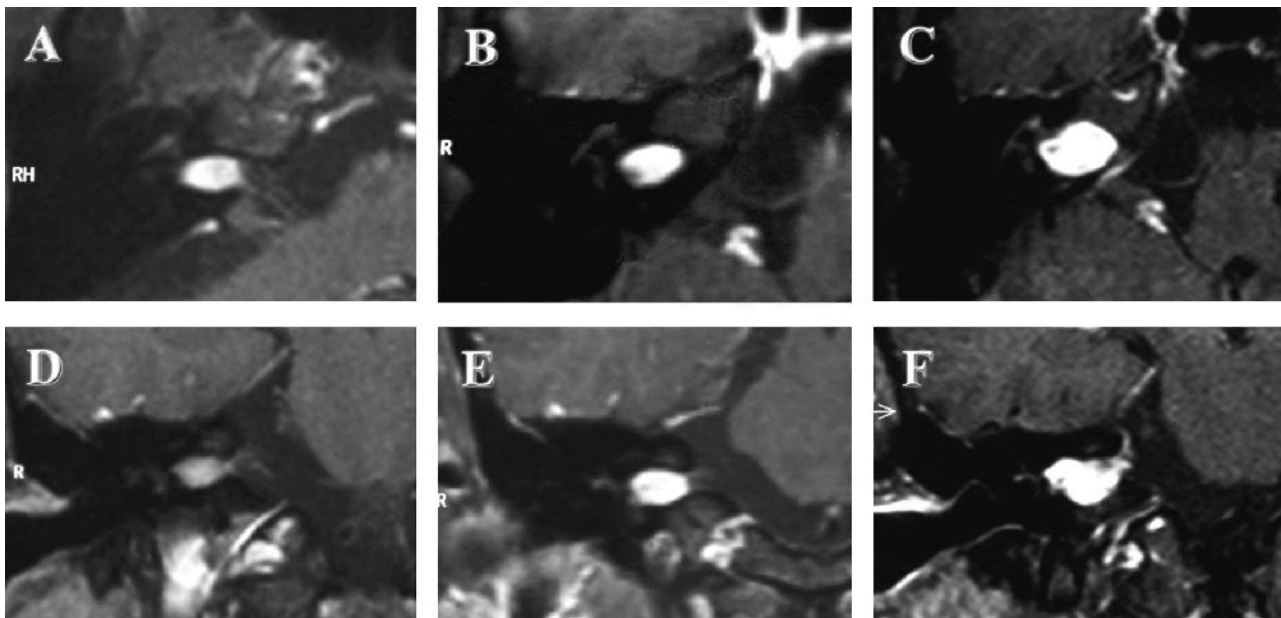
T1-weighted, post-gadolinium-enhanced MRI scans of the cerebellopontine angle from Case 1. Axial images (A–C) and coronal sections (D–F). (A and D) Pre-gamma knife MRI scans demonstrating a right-sided 1.0-cm VS, with scans at 6 months (B and E) and 20 months (C and F) after radiation. Slight tumor involution seen in B was followed by rapid regrowth to 1.5 cm at 1 year after radiosurgery (MRI scan not shown).
